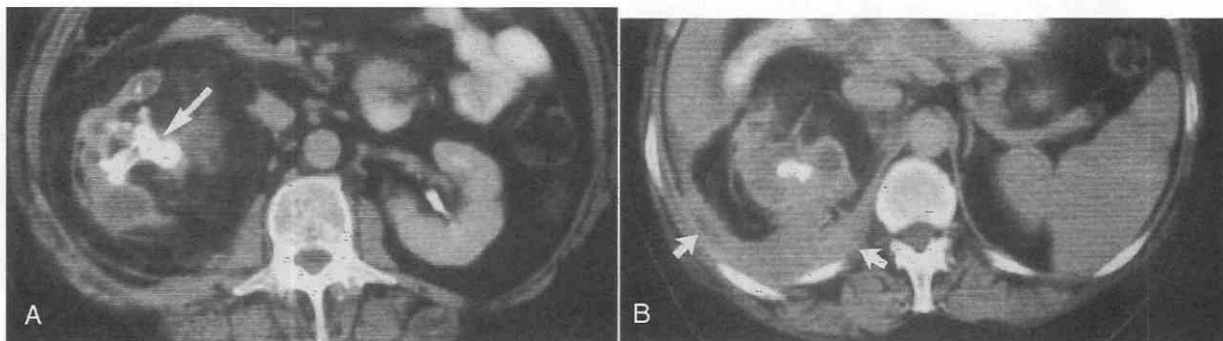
Xanthogranulomatous pyelonephritis with a contracted kidney. A, A staghorn calculus (arrow) is present in the right renal pelvis. The right kidney is small and replaced by oval, fluid-density areas. B, A more cephalad CT scan shows extensive chronic inflammatory change (arrows) in the posterior pararenal space.
